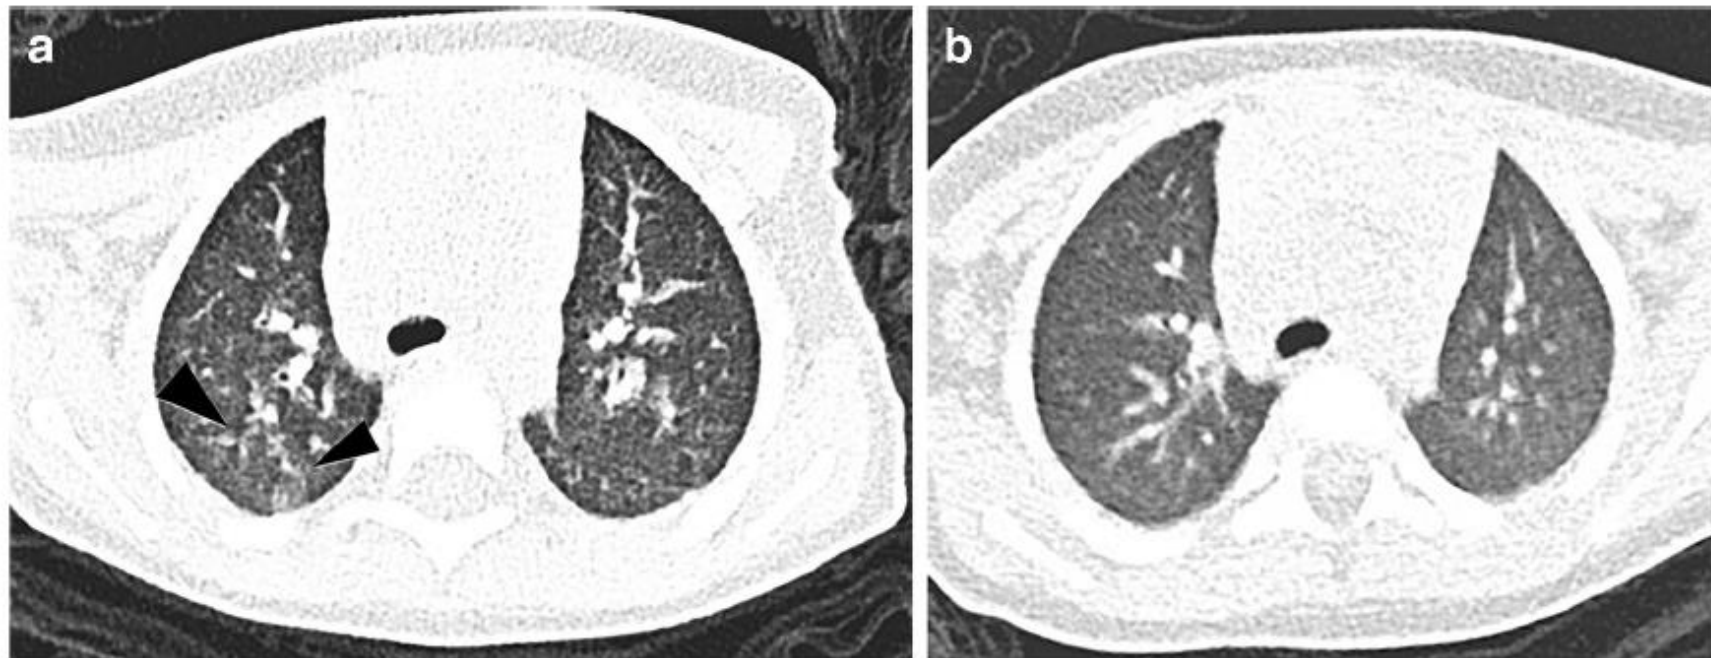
Axial non-enhanced chest CT in a boy age 1 year 5 months (Patient 1 in Table 1). a Four days after admission there is patchy ground-glass opacification (*arrowheads*) of the right upper lobe. b Five days subsequently, during antiviral treatment, the appearances have normalised
